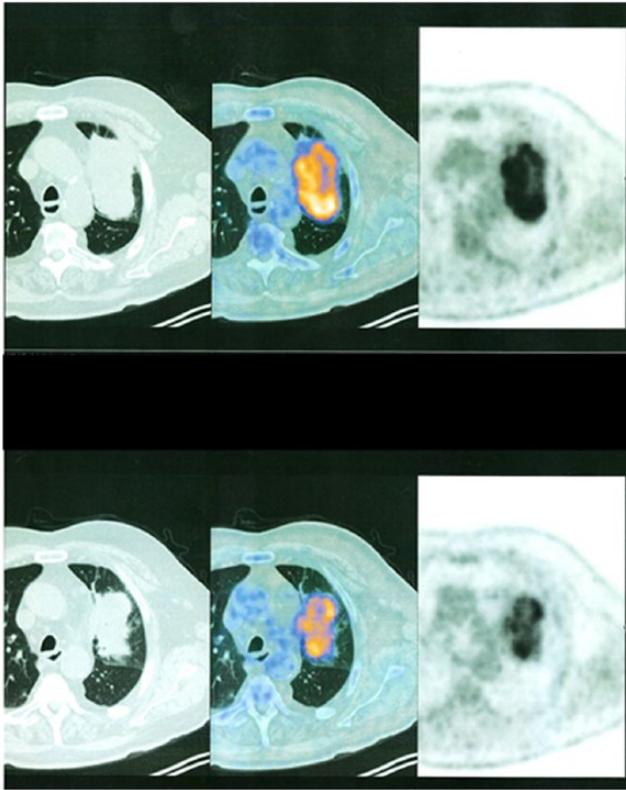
PET-CT scan after chemotherapy and before surgical exploration.
